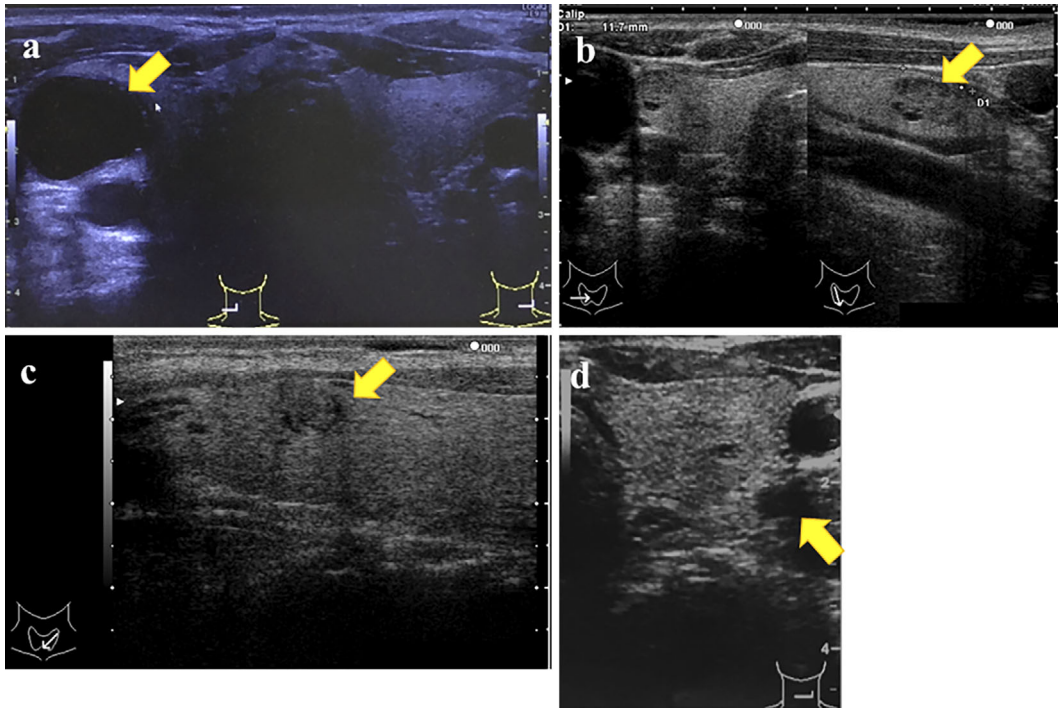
Cervical ultrasonography. (a) A cyst 2 cm in diameter in the right thyroid lobe (arrow). (b) A solid nodule 9 mm in diameter in the right thyroid lobe (arrow). (c) A solid nodule 7 mm in diameter in the left thyroid lobe (arrow). (d) A solid nodule 15 mm in diameter in the lower pole of the left lobe of the thyroid glands (arrow).
